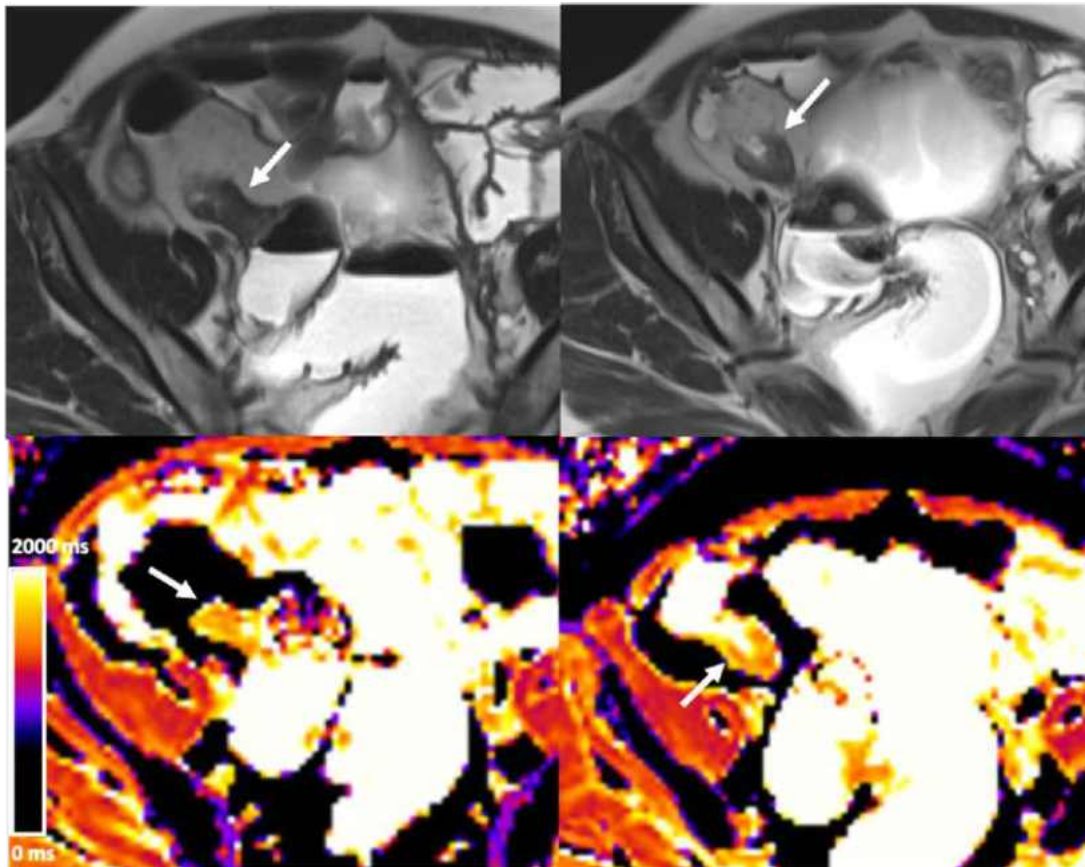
T1-mapping images of a CD stricture in the neoterminal ileum in a 41-year-old woman with an ileosigmoid anastomosis. Axial T2-weighted MR images in the top row show a thickened bowel wall (arrows). The bottom row contains corresponding axial parametric maps of the ileum produced from native T1 relaxometry (modified Look-Locker inversion recovery), with arrows pointing to the same stricture. The parametric maps are color coded according to T1 values of the tissue (inset, bottom left): yellow and orange represent higher T1 values. Bowel wall T1 estimates are increased in patients with ileal CD compared with uninvolved segments. In this case, endoscopic findings showed a short-segment stricture, which could be traversed with a pediatric endoscope, and 5 cm of endoscopic inflammation proximally.
